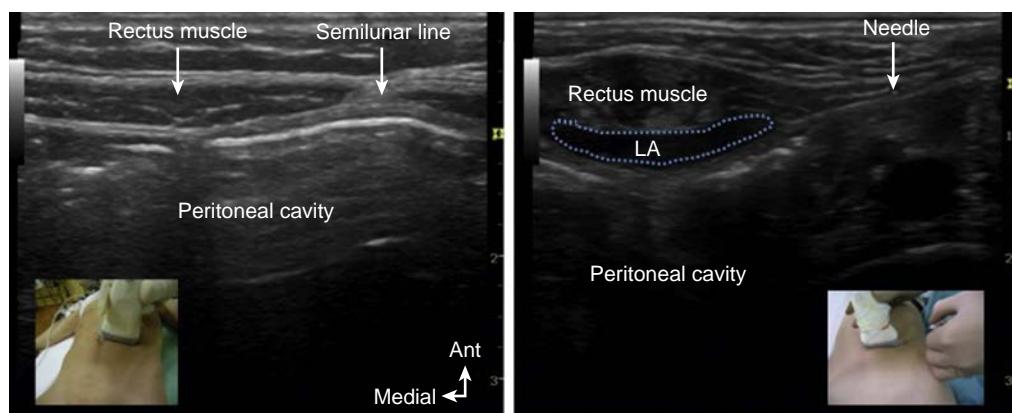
Ultrasound of paraumbilical block. Insertion of the needle close to the posterior fascia of the rectus muscle and injection of the local anesthetic creating a biconvex black cloud.
